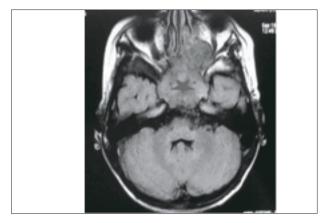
MRI T1, axial sequence: isointense mass within sphenoid with involvment of ethmoid and left orbit
